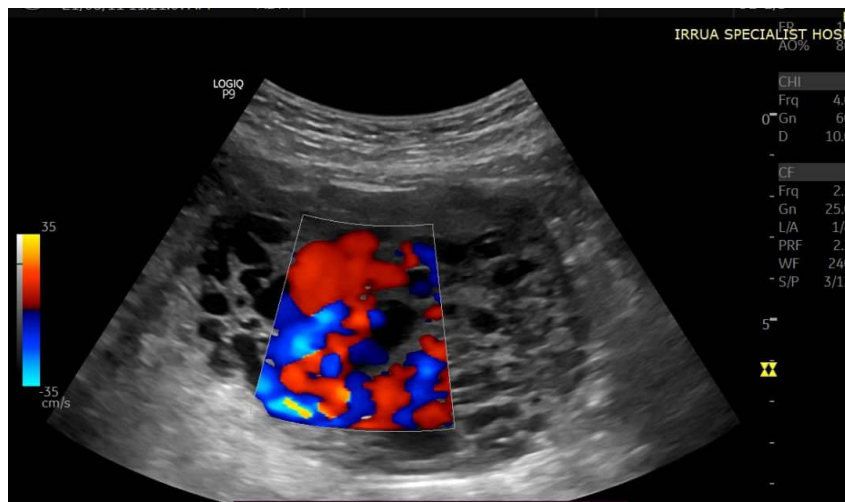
On colour doppler interrogation, the lesions are seen as vascular structures, demonstrating intense myometrial hypervascularisation and turbulent flow with some areas showing a mosaic pattern
